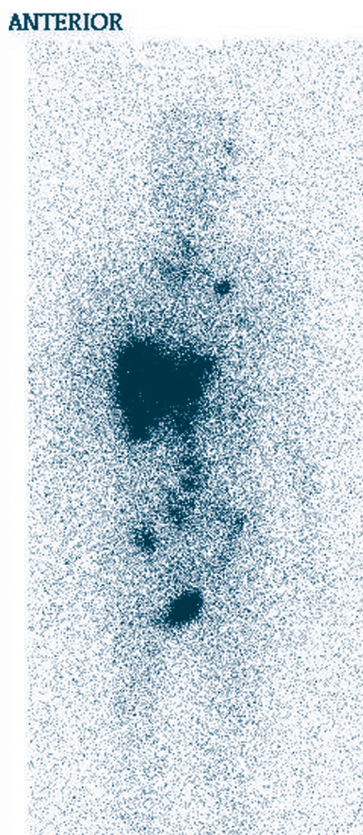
Whole body scintigraphy with ^{131}I -MIBG prepared in-house, showing multiple sites of metastases in a patient with malignant pheochromocytoma.
